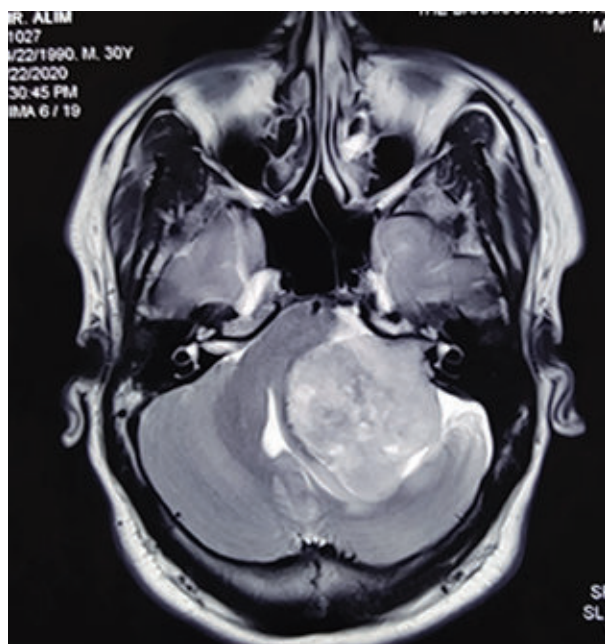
Preoperative MRI of VS
